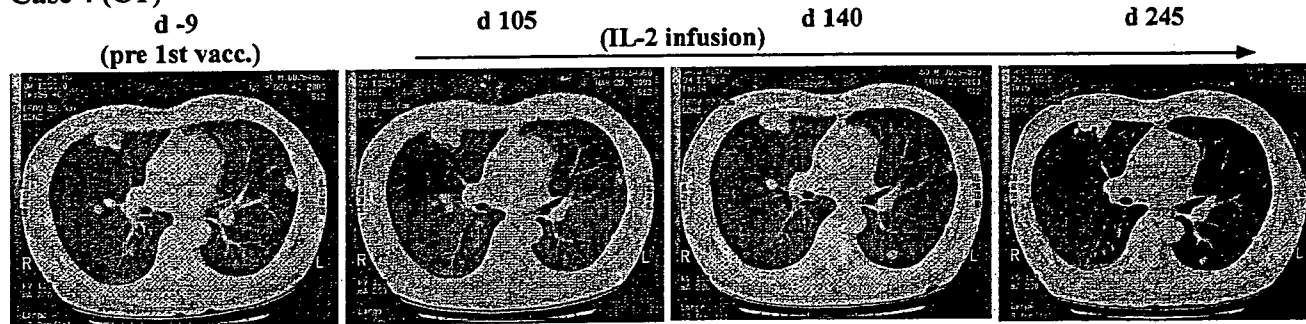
Size change of the lung metastases in Cases 1 and 4 during the observation period after GVAX vaccination. (A) In Case 1, the size of the right hilar tumor, the largest metastatic lesion, became smaller after 1 week of low-dose IL-2 (d 166, day 166) and decreased by 30% after 1 month of low-dose IL-2 compared with the tumor just after the 10th vaccination. Chest X-ray films are presented. (B) In Case 4, the size of the left lung metastasis became smaller during vaccination as shown on two films for comparison between prevaccination and 105 days after the 1st vaccination. After the start of low-dose IL-2 between days 105 and 245, both the metastatic lesions in the left lung and those in the right lung became smaller. CT scan films are presented.
